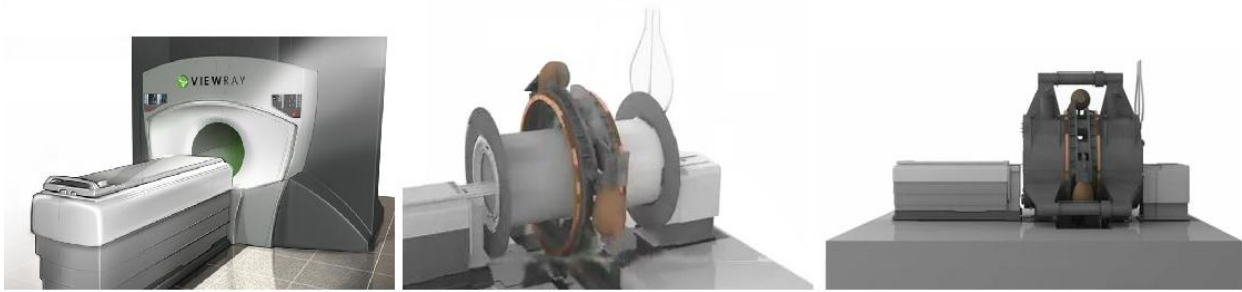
The ViewRay System, a hybrid MRI-⁶⁰Co radiotherapy device (images courtesy of ViewRay, Inc.).
